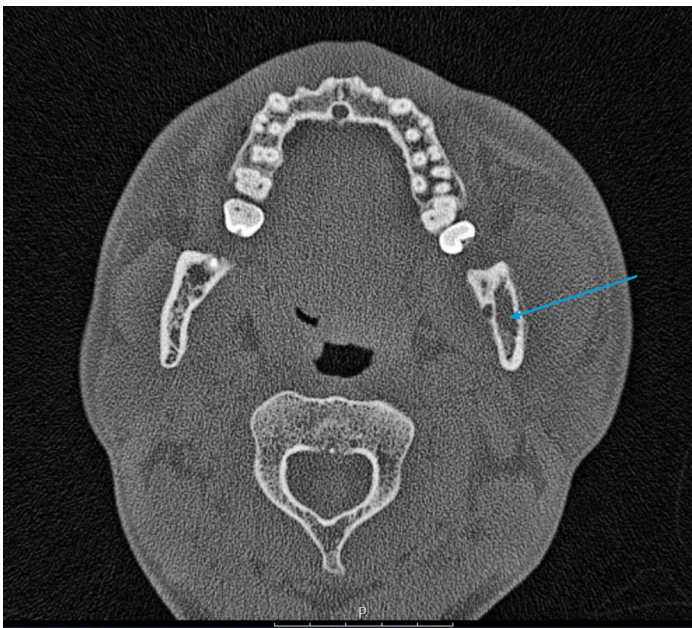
CT Head (axial) at level of mandibular foramen showing loss of trabeculation in the left ascending ramus.
